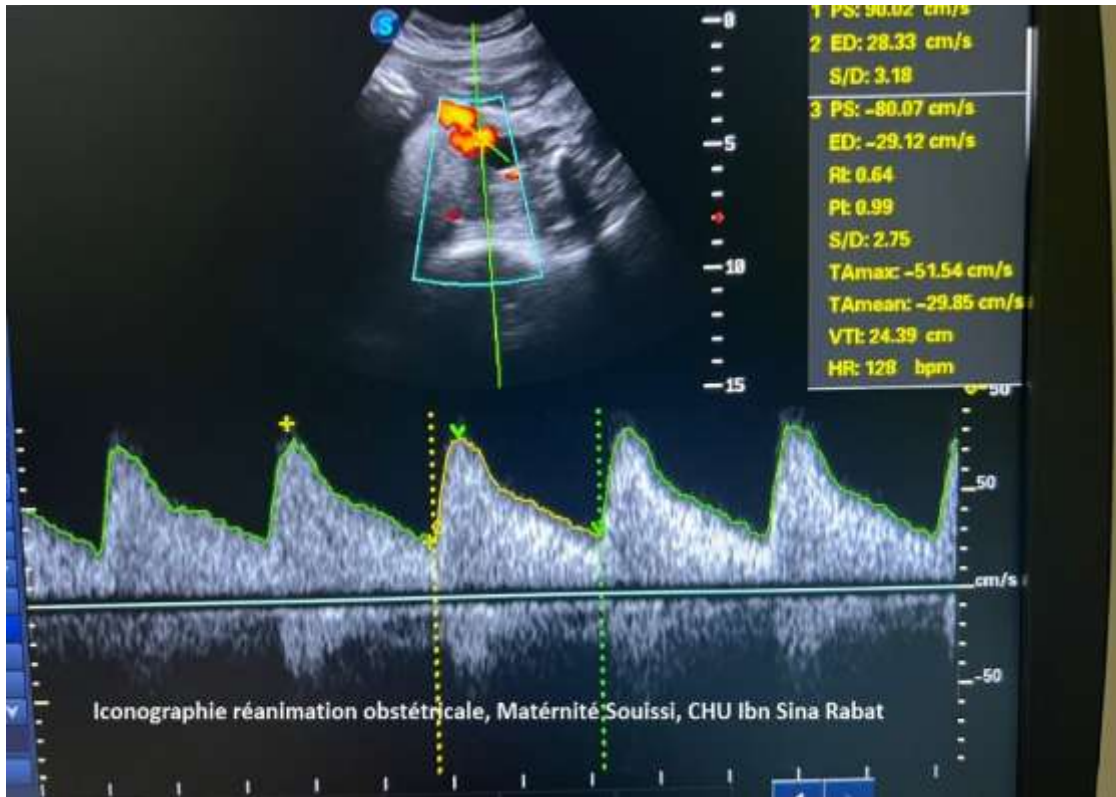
Fetal Doppler ultrasound at 33 weeks of amenorrhea, revealing no abnormality.
